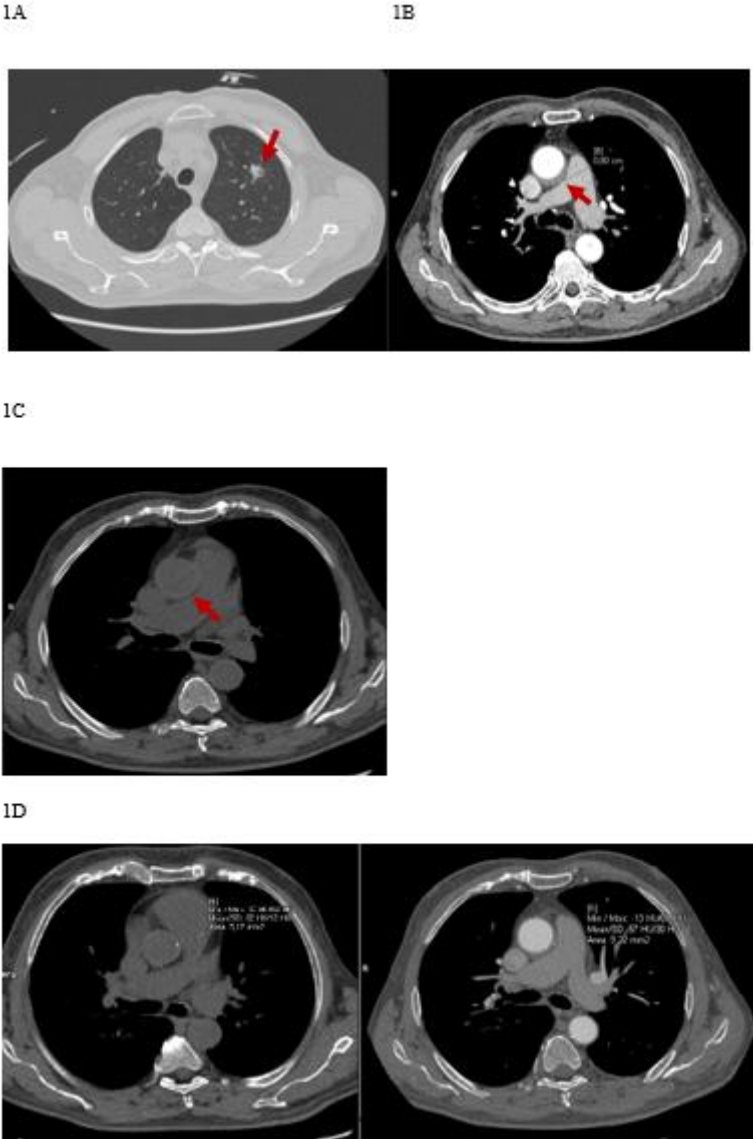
A – axial chest computed tomography (CT) demonstrating multiple irregular spiculated pulmonary nodules (arrow); B – contrast-enhanced axial CT image showing focal thickening of the posterior wall of the ascending aorta (arrow), measuring approximately 8 mm, consistent with an aortic intramural hematoma; C – axial noncontrast CT of the thorax demonstrating hyperdense thickening of the ascending aortic wall (arrow), consistent with an
